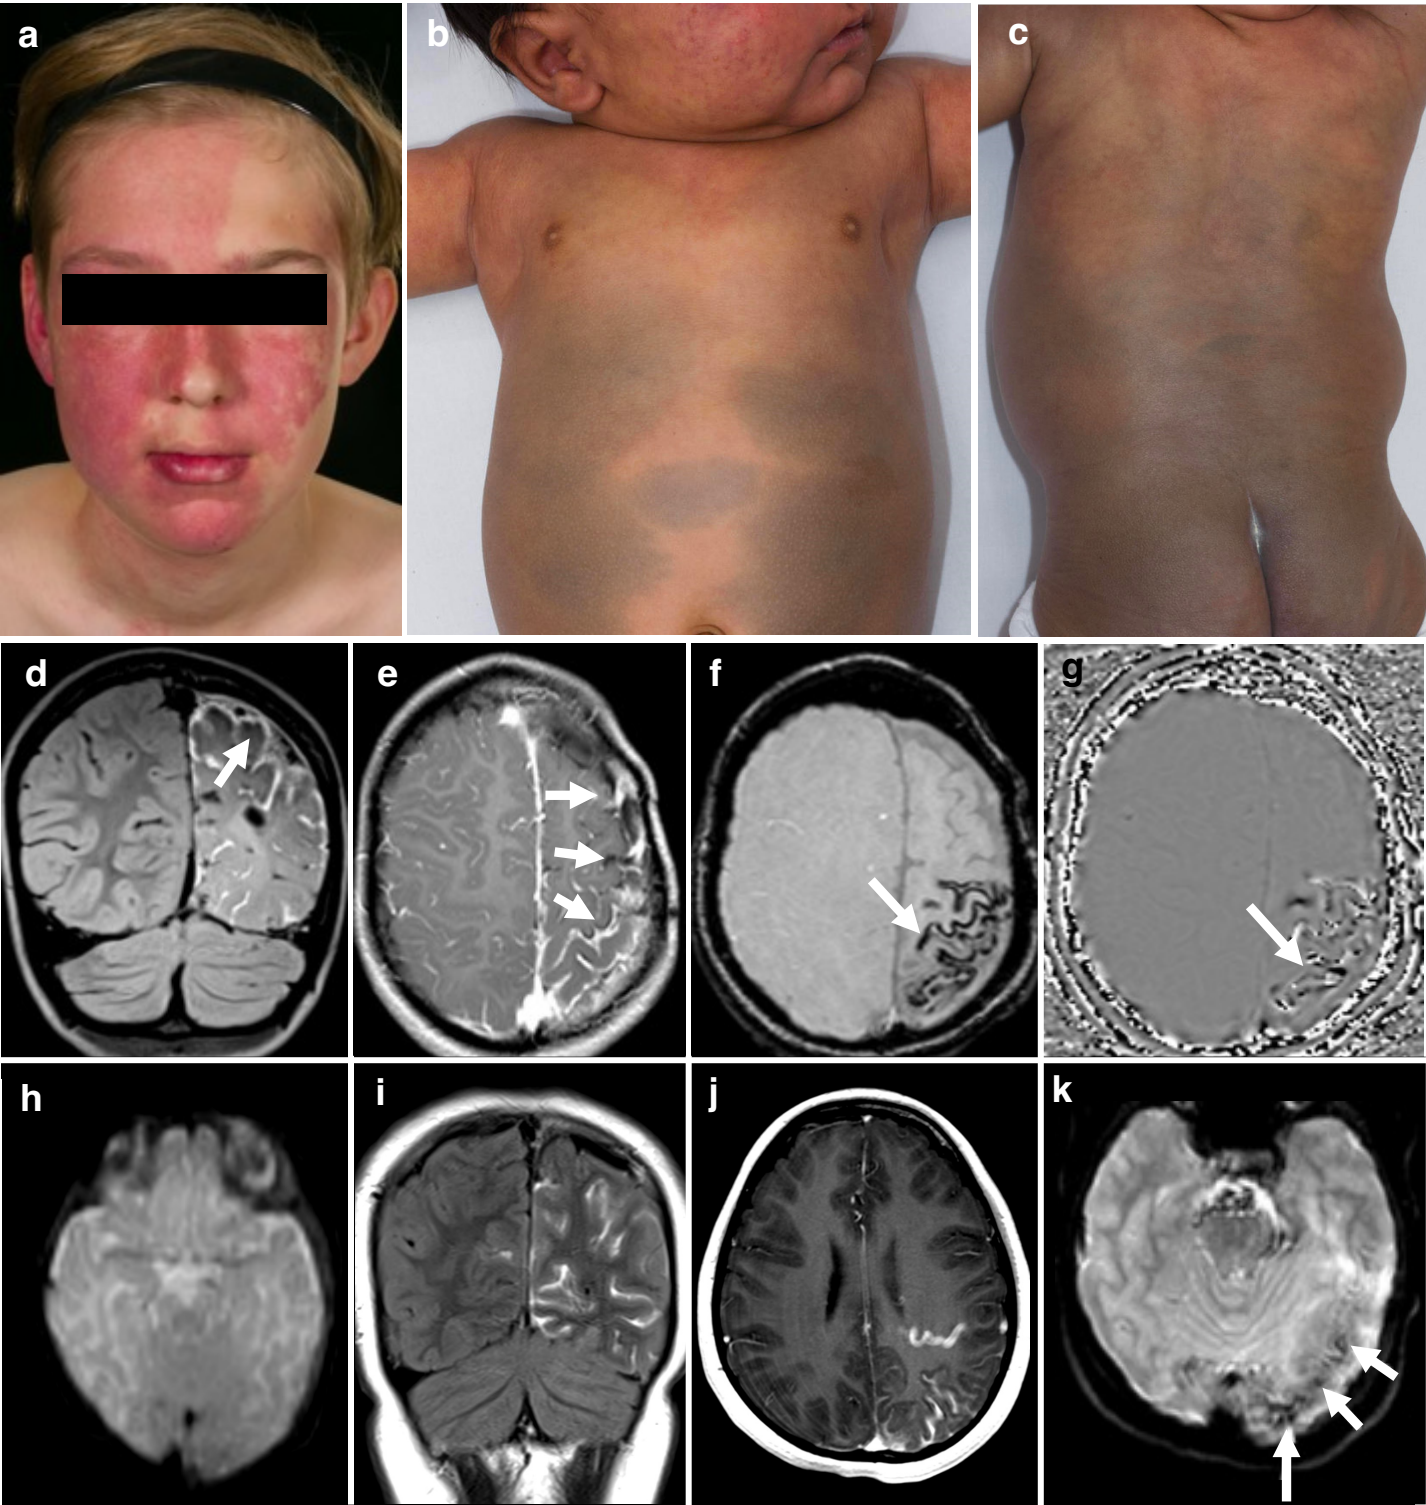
Phenotyping and radiological findings in *GNAQ/GNA11* mosaicism. (a) Clinical features of a SWS syndrome patient with a capillary malformation of the head involving the critical forehead area, associated with glaucoma in the right eye. This patient had hypocalcaemia with low levels of ionised and total calcium and increased PTH. (b and c) Clinical features of a PPV-DM patient exhibiting a capillary malformation (with naevus anaemicus) on the face, upper trunk and extensive areas of dermal melanocytosis. (d and e) Contrast enhanced FLAIR and T1-weighted MR images of a patient with SWS show left frontal, parietal and occipital pial angiomatosis (vascular malformation, arrows). (f) Susceptibility-weighted imaging (SWI) and (g) SWI phase map depicting vascular calcifications (arrow). This patient had low levels of ionised calcium and total calcium with PTH in the normal range. (h) Axial DWI b0 image does not show calcifications on the initial MRI study. (i-k), after 8 years time. (i) Coronal Fluid-attenuated inversion recovery (FLAIR) after administration of a gadolinium-based contrast agent shows left parietal and occipital (and some contralateral) sulcal enhancement in keeping with pial angioma. (j) Axial post-contrast T1-weighted image depicts the sulcal enhancement and a prominent draining vein. (k). DWI b0 image at follow-up shows foci of increased susceptibility which are suggestive of calcification. Patients and/or parents/guardians provided written consent for the publication of images.
